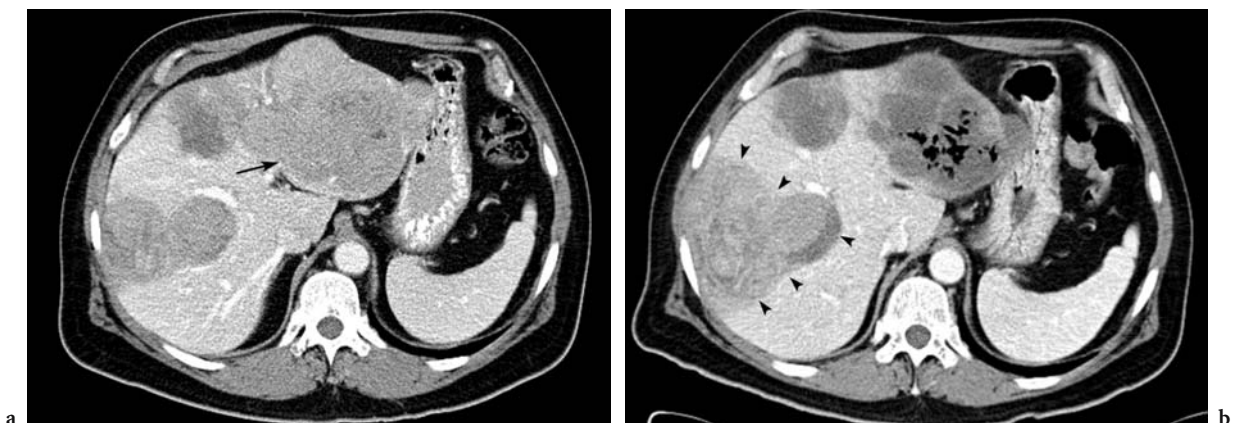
Fifty-four-year-old male with metastatic neuroendocrine tumor of unknown primary. (a) Pre-embolization venous-phase CT image of the liver shows the largest metastasis in the left lobe (*arrow*). (b) Venous-phase CT image of the liver obtained 7 wks post-embolization of the LHA using 6 vials of tris-acryl gelatin microspheres shows that the largest metastasis has decreased in size and enhancement, but contains a moderate amount of gas. The patient complained of fever and vomiting, which resolved with antibiotic therapy. The lesion was not aspirated or drained. We suggest percutaneous drainage only if a patient becomes septic or if there is no response to antibiotics. *Arrowheads* denote interval growth of a right lobe metastasis
